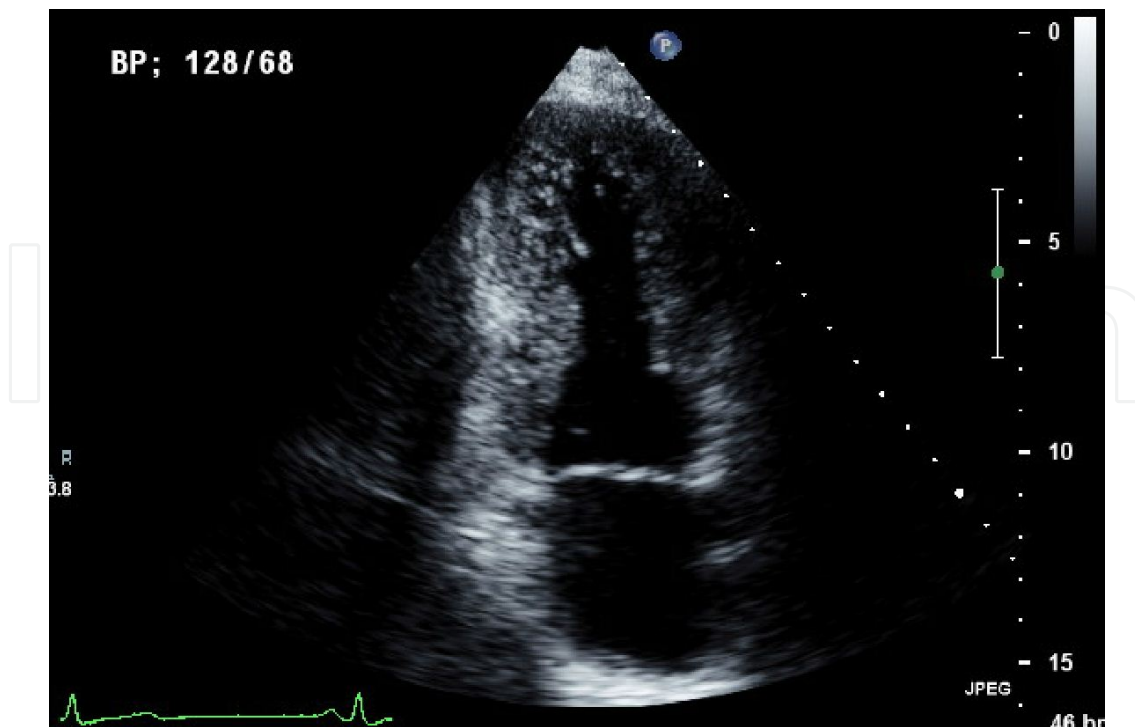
Apical 2 chamber view showing prominent trabeculations in the apex and inferior walls consistent with Isolated Left Ventricular Non-Compaction.
